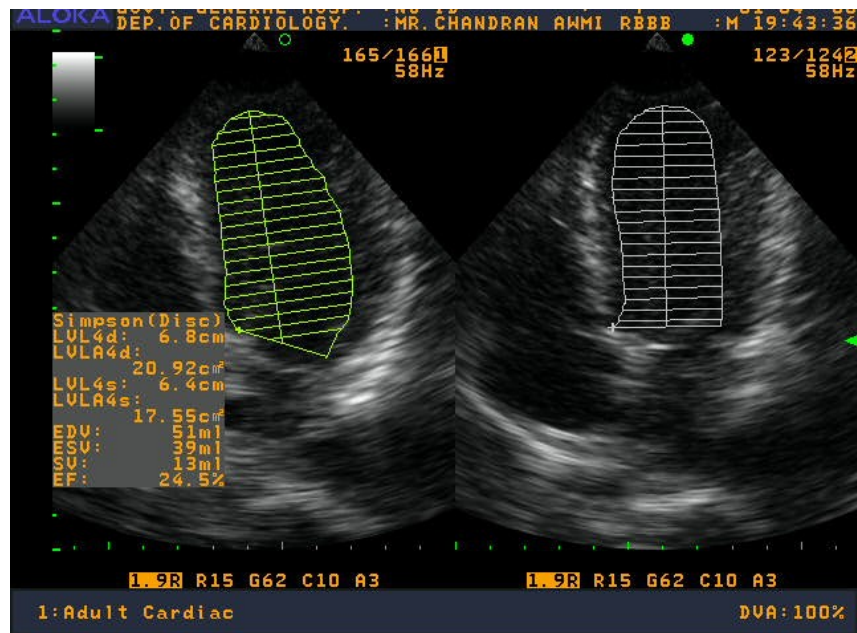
2D echo–apical 4 chamber view. LVEF assessment by modified Simpson’s method.
